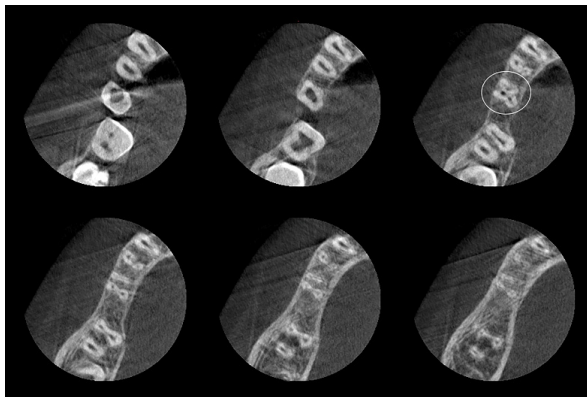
CBCT axial scan of mandibular second premolar with three canals.
